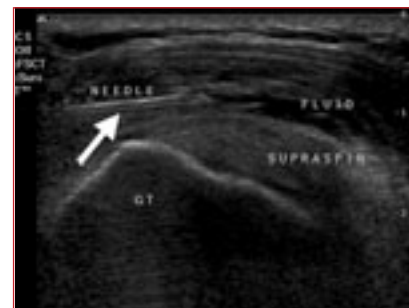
Ultrasound-guided injection into subacromial bursa.
